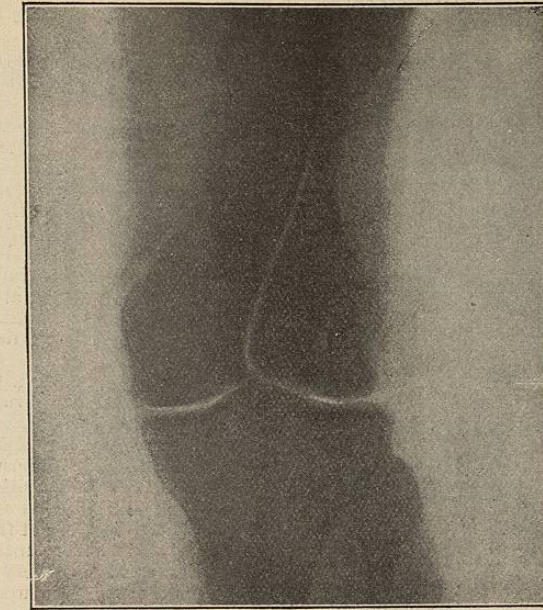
Radiograph showing Fracture of the External Condyle of the Femur.
